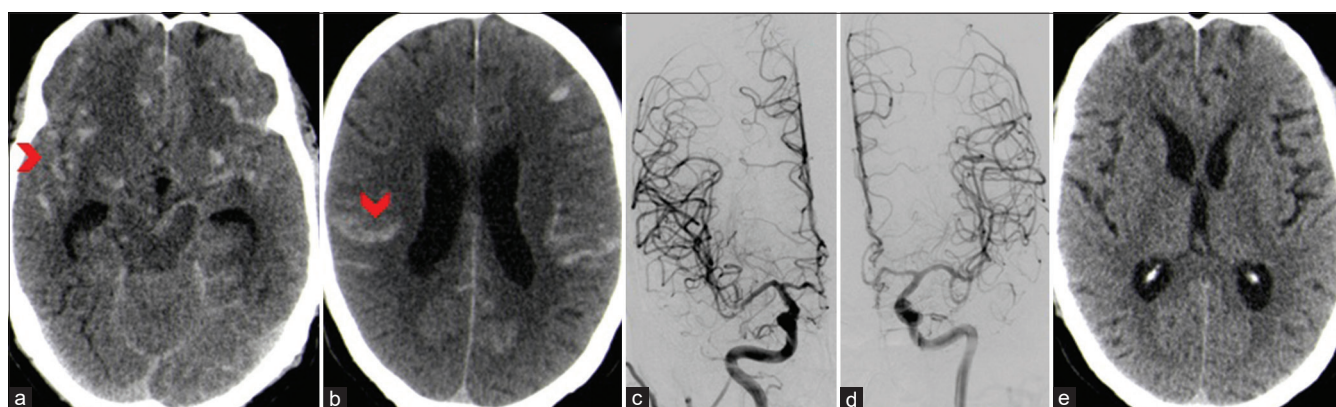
(a and b) Noncontrast computed tomography head showed acute subarachnoid hemorrhage (red arrow head) in bilateral Sylvian fissure, anterior interhemispheric fissure and in bilateral frontal sulci. (c and d) Cerebral digital subtraction angiography of bilateral internal carotid artery showed no evidence of aneurysm and vascular malformation. (e) Noncontrast computed tomography head was done after 2 weeks showed interval complete resolution of subarachnoid hemorrhage
